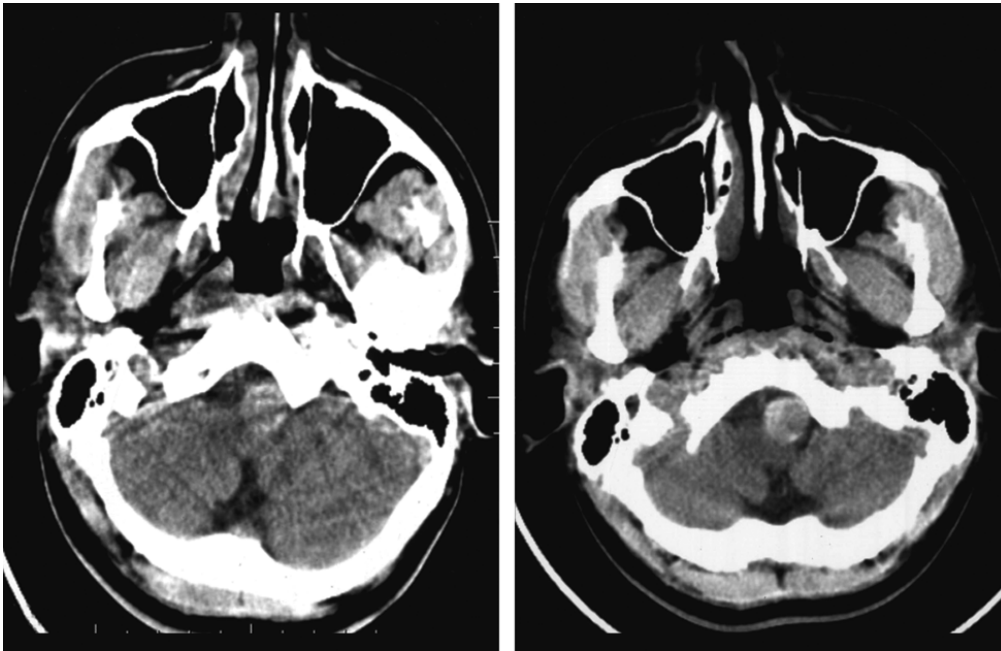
Computed tomography—perimedullary bleed left (posterior inferior cerebellar artery aneurysm)
